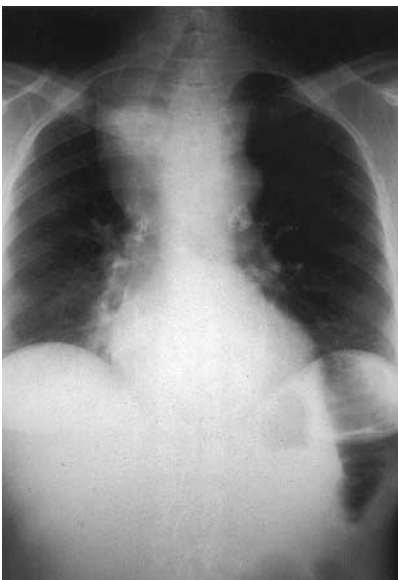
Chest radiograph demonstrates characteristic narrowing that is associated with tracheal invasion by tumor.
